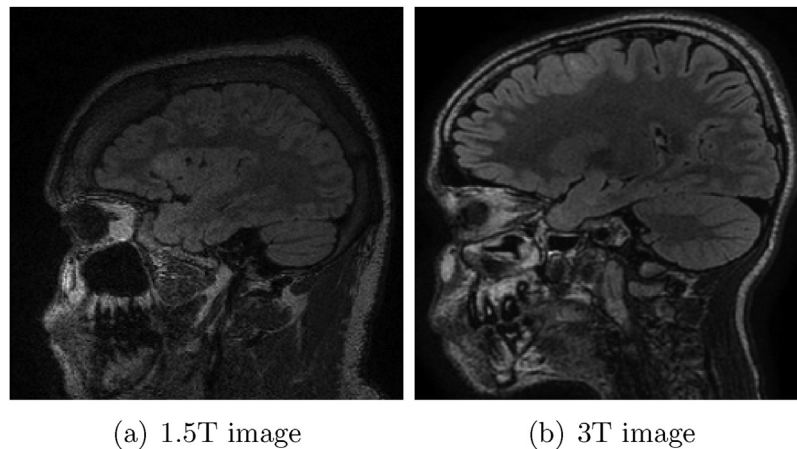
Sample MRI-scans of brain acquired with 1.5T and 3T scanners. The difference in signal to noise ratio (SNR) can be observed from these images.
